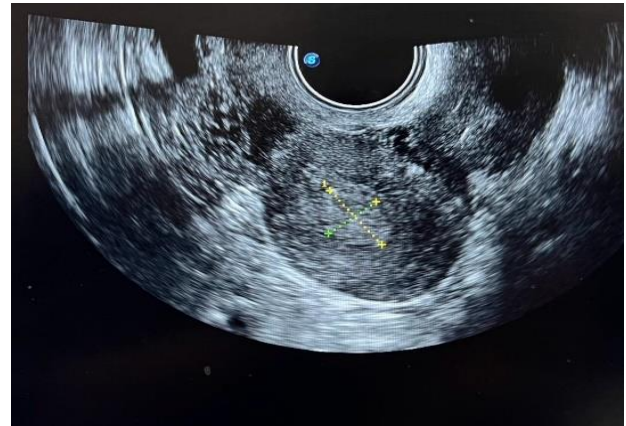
Transvaginal ultrasound showing mixed echogenic haemorrhagic collection in the uterus.
